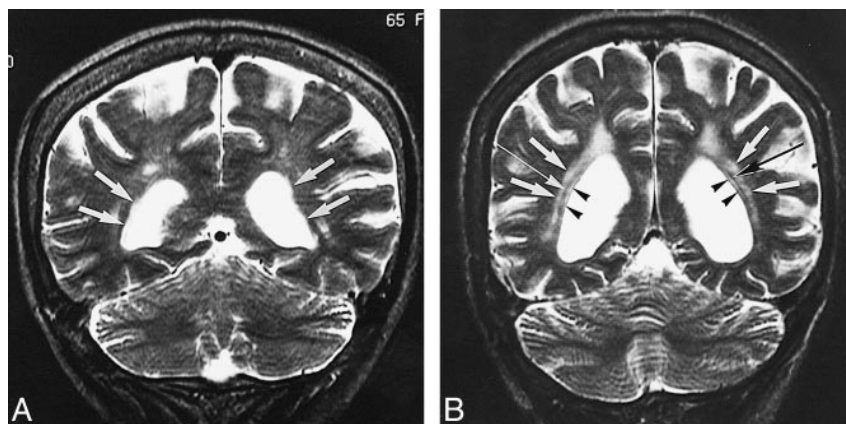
A, Coronal high-resolution T2-weighted image (4000/128/2) of a 65-year-old woman shows linear hyperintensities of the tapetum on both sides (arrows).
